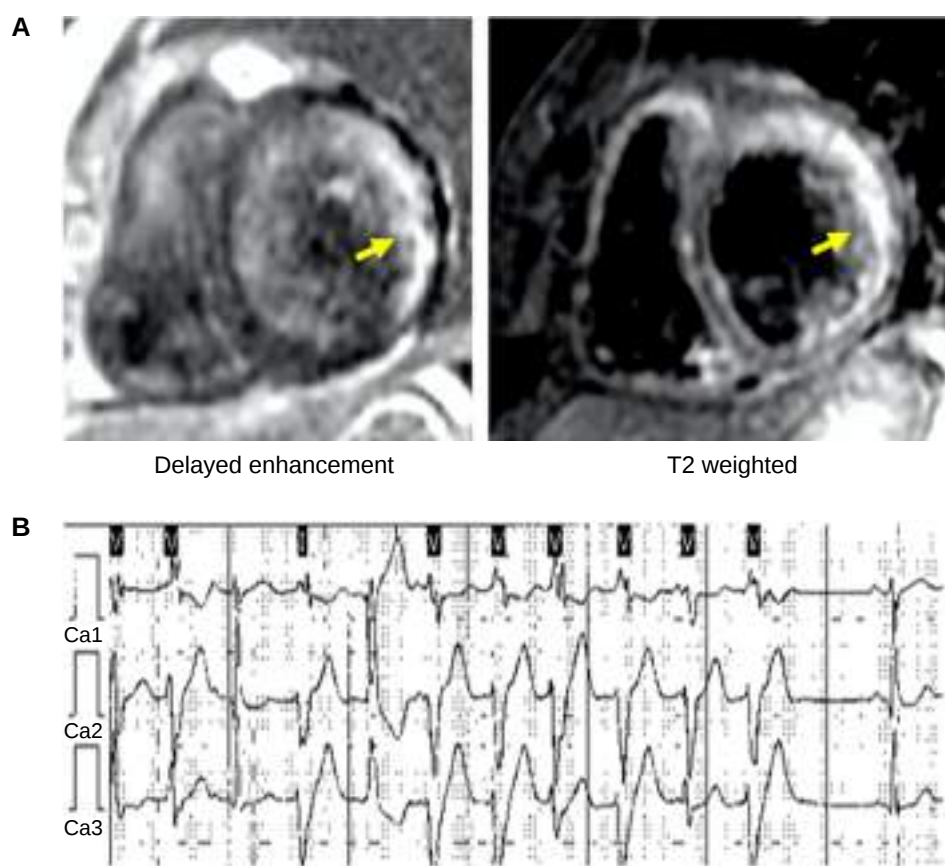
CMR (A) revealing extensive lateral wall LGE and myocardial oedema on T2-weighted imaging; acute inflammation identified as the underlying substrate for polymorphic non-sustained ventricular tachycardia (B).
